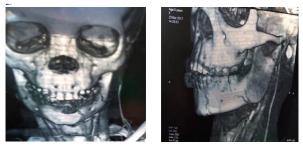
Pretreatment findings-CT angiogram showing venous malformation with the feeding vessel.
